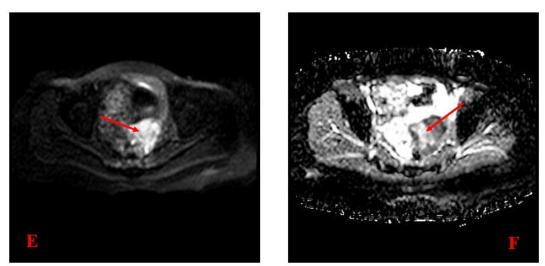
E, F: E- Axial DWI shows restricted pattern, F- ADC map shows low signal intensity with ADC value 0.75 x 10⁻³ mm²/sec.
